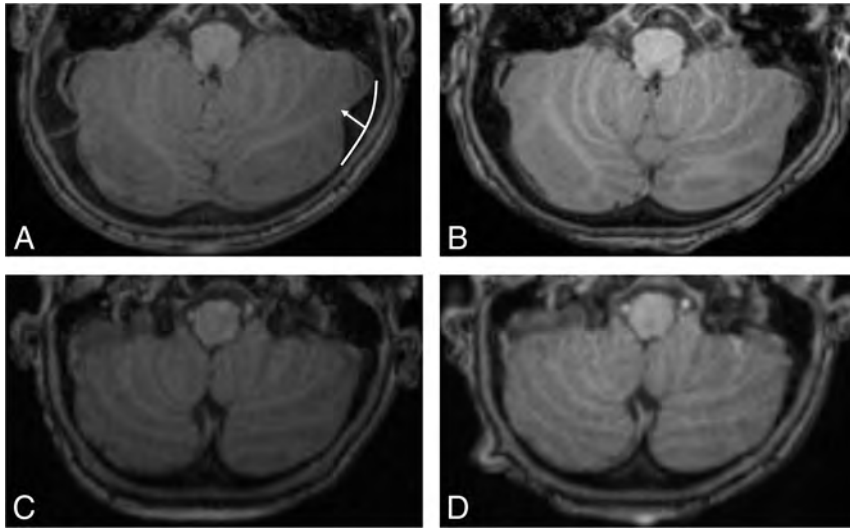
A, T1-weighted axial images demonstrate a progressive decrease in the size of the posterior fossa horns in a patient who underwent hematopoietic stem cell transplantation at 1 year of age. The height of the posterior fossa horn is measured from the expected curvature of the inner table (curved white line) to the tip of the horn (A, white arrow). The posterior horns measure 6.3 mm R/5.4 mm L at 0.9 years (A). They are 4.1 mm R/3.2 mm L at 1.8 years (B) and 2.0 mm R/1.0 mm L at 4.1 years (C). D, They are 0 mm R/0 mm L at 5.9 years (D).
